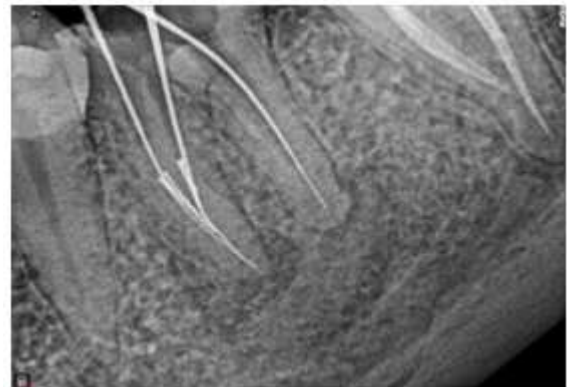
Two Month Follow Up Radiograph Showing Healing Periapical Radiolucency #36 And Bypass of Separated Instrument with WL
